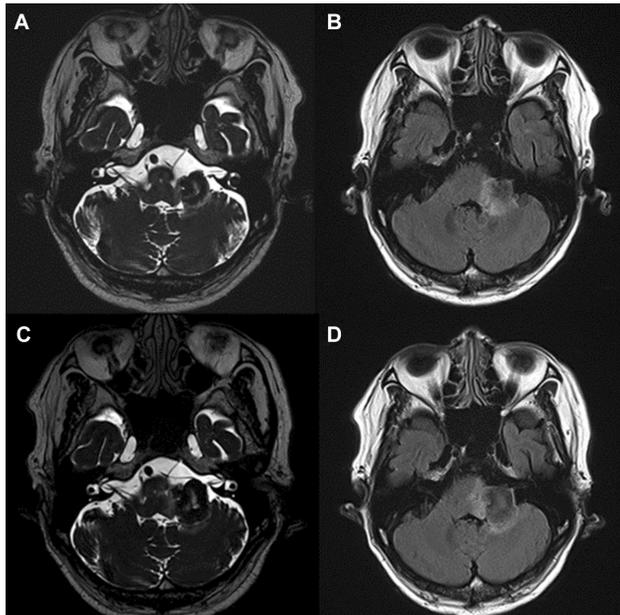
Radiographic images of the brain. (A) Initial heavy T2-weighted magnetic resonance (MR) image showing a mass in the left cerebellopontine angle (CPA). (B) Initial fluid-attenuated inversion recovery image showing an edematous region around the mass. (C, D) Second MRI within a 2-week interval showing a lesion with edematous changes in the surrounding.
